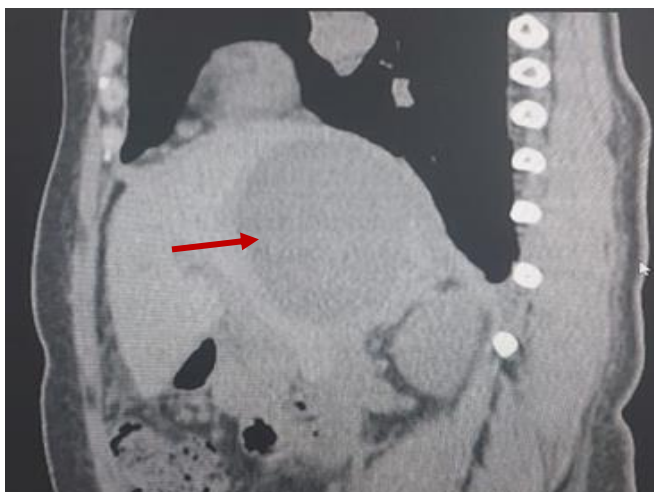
Abscess - CT scan – Sagittal.
